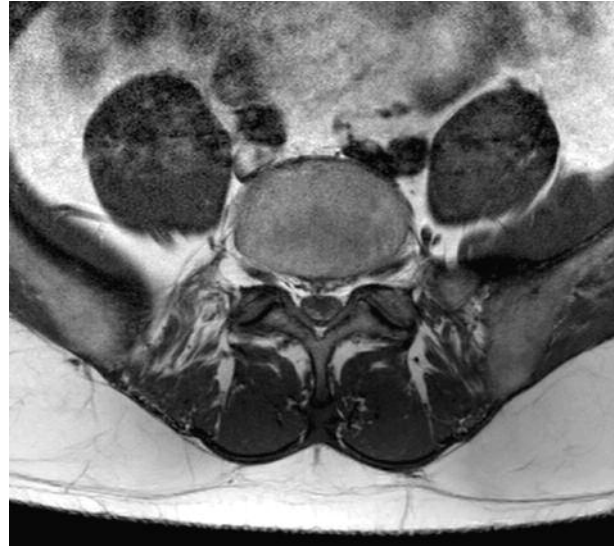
Axial T1-weighted MRI showing a “curtain sign” typical for a spinal subdural space occupying lesion.
